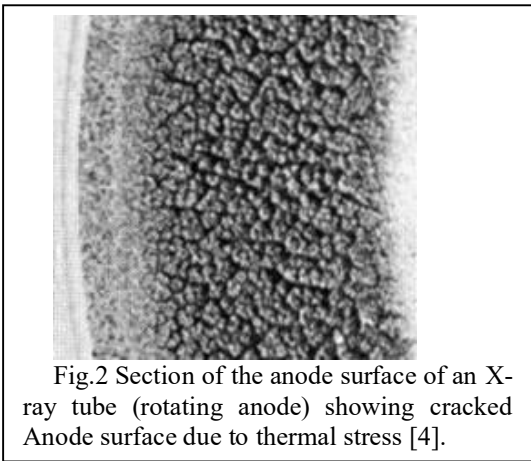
Section of the anode surface of an X-ray tube (rotating anode) showing cracked Anode surface due to thermal stress [4].
